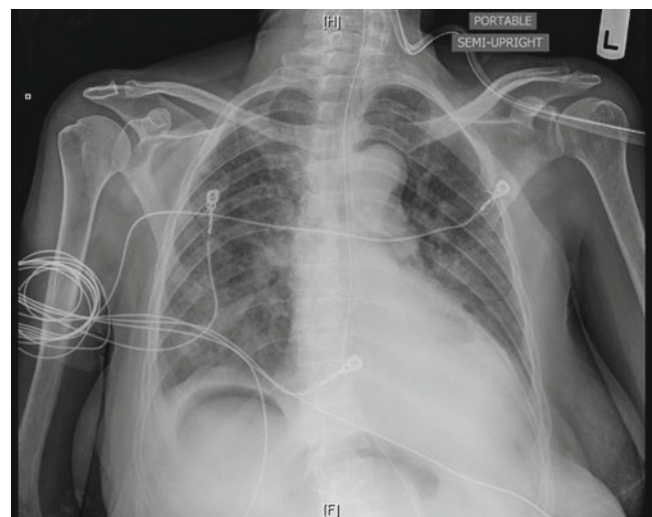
Perforated viscus. Chest X-ray demonstrates subdiaphragmatic free air above the dome of the liver
